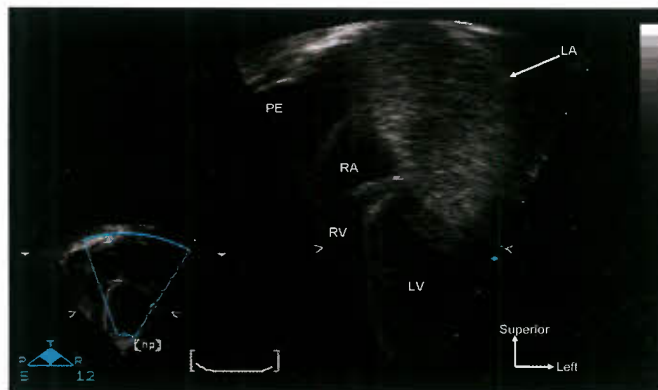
Apical four-chamber view during administration of agitated saline contrast in the left antecubital vein demonstrates dense opacification of the left atrium (LA) supportive of the suspected diagnosis of a left superior vena cava draining directly into the roof of the LA. (This patient also has a moderate pericardial effusion [PE].) LV, left ventricle; RA, right atrium; RV, right ventricle.
